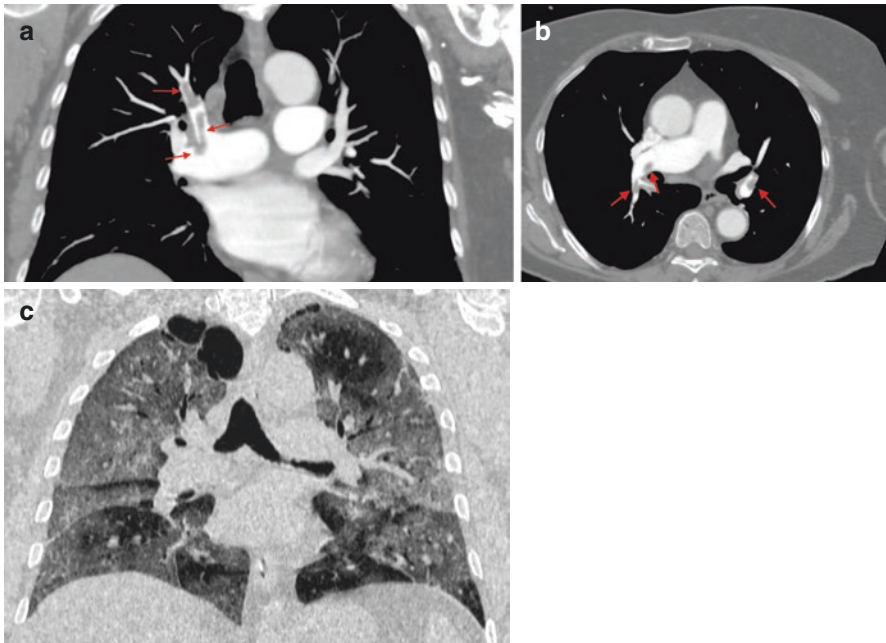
Acute pulmonary embolism in patients with COVID-19 pneumonia. Emboli present in right upper lobe artery (a) and intermediate and left lower lobe artery (b) at CT pulmonary angiography. Bilateral lung involvement and ground-glass opacities at high-resolution CT lung scan (c)
